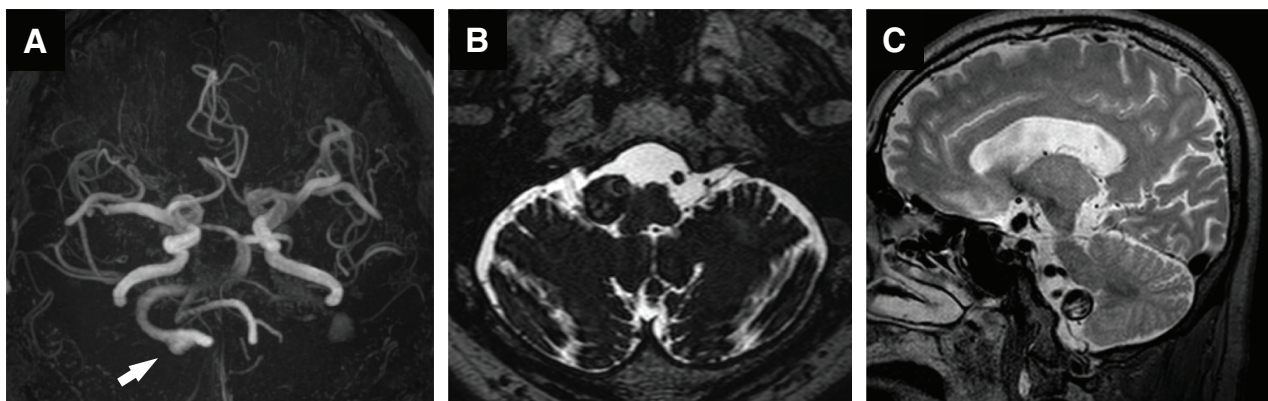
(A) MRA shows a fusiform aneurysm of the right VA (arrow). (B and C) T2-weighted image shows a partially thrombosed aneurysm
